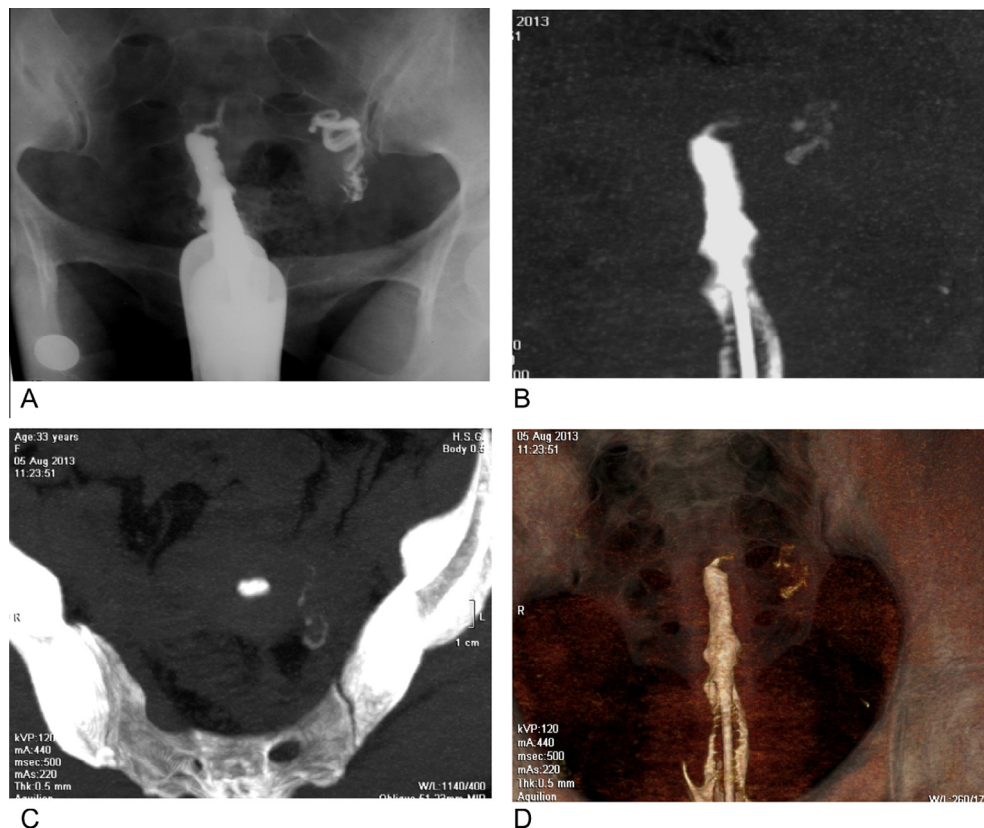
Unicornuate uterus. (A) The X-ray HSG revealed Unicornuate uterus with single uterine horn and a single left fallopian tube. The MDCT VHSG revealed Unicornuate uterus with single uterine horn and a single fallopian tube. Although the wall has irregular outline yet there was no evidence of intrauterine adhesion (B and C) Maximum intensity projections. (D) Volume rendering reconstruction.
